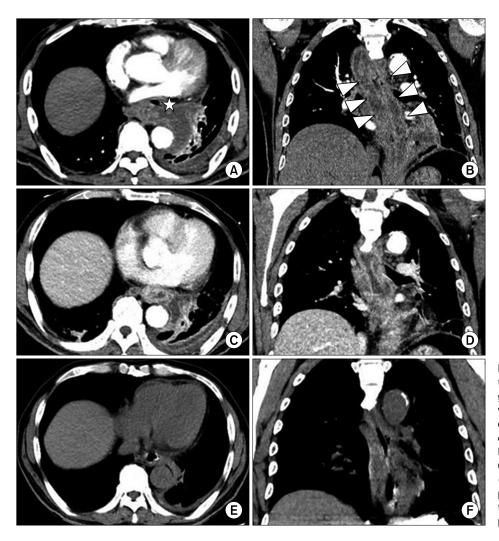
CT findings before and after treatment of phlegmonous esophagitis. (A) Edematous esophagus with air-bubble formation (asterisk) on the CT axial view. (B) Diffuse esophageal wall thickening and dilatation (white arrowheads) on the CT coronal view before treatment. (C, D) Five days after the first procedure. (E, F) Four days after the second procedure. CT, computed tomography.
